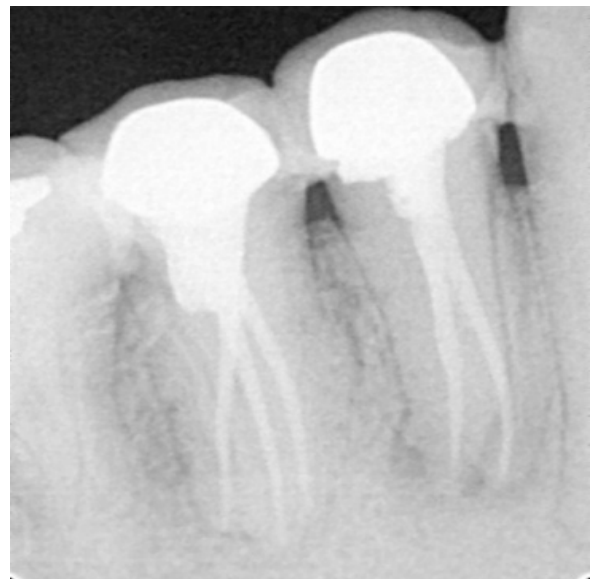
Fifteen month's follow-up radiograph showing Zirconia full coverage Crown and healthy status of periapical tissues
